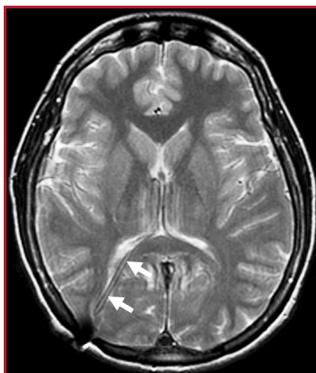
Slit ventricle is shown. Axial T2-weighted MRI scan demonstrating collapse of the lateral ventricles in a patient with slit ventricles. A portion of the shunt ventricular catheter is seen (white arrows). The finding of slit ventricles does not indicate a properly functioning shunt.
